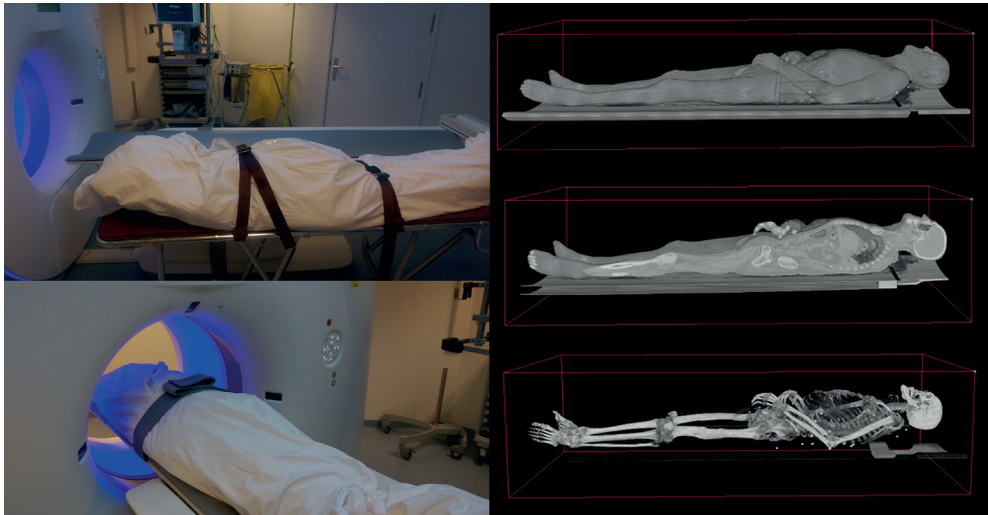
Postmortem computed tomography
